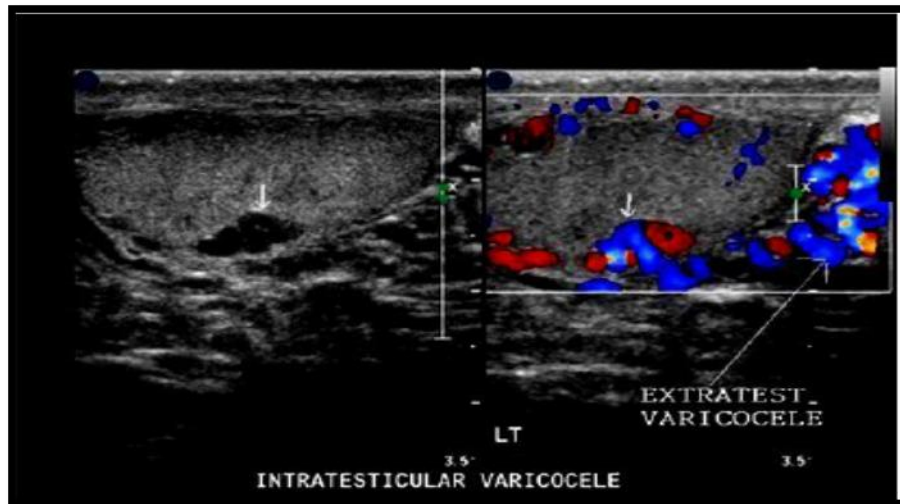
shows, the left scrotum shows a large extra testicular Varicocele (long arrow in image on left). Also present are a few dilated vessels (more than 2 mm. each) in the sub capsular part of the left testes (small arrow in color Doppler image). (Henry et al, 2009).
